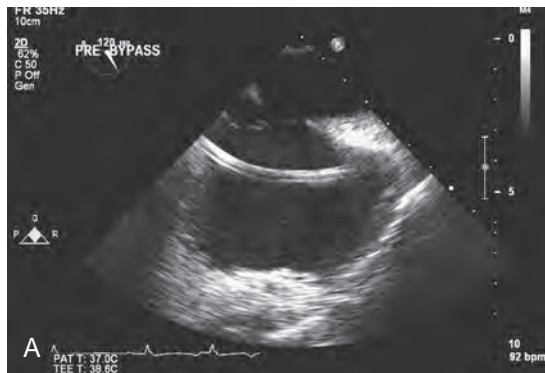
(A) Modified midesophageal, bicaval, transesophageal echocardiogram demonstrates a percutaneously placed coronary sinus catheter entering the coronary sinus (left side). (B) Intraoperative fluoroscopic image was taken after contrast injection into the distal tip of a correctly placed coronary sinus catheter.
